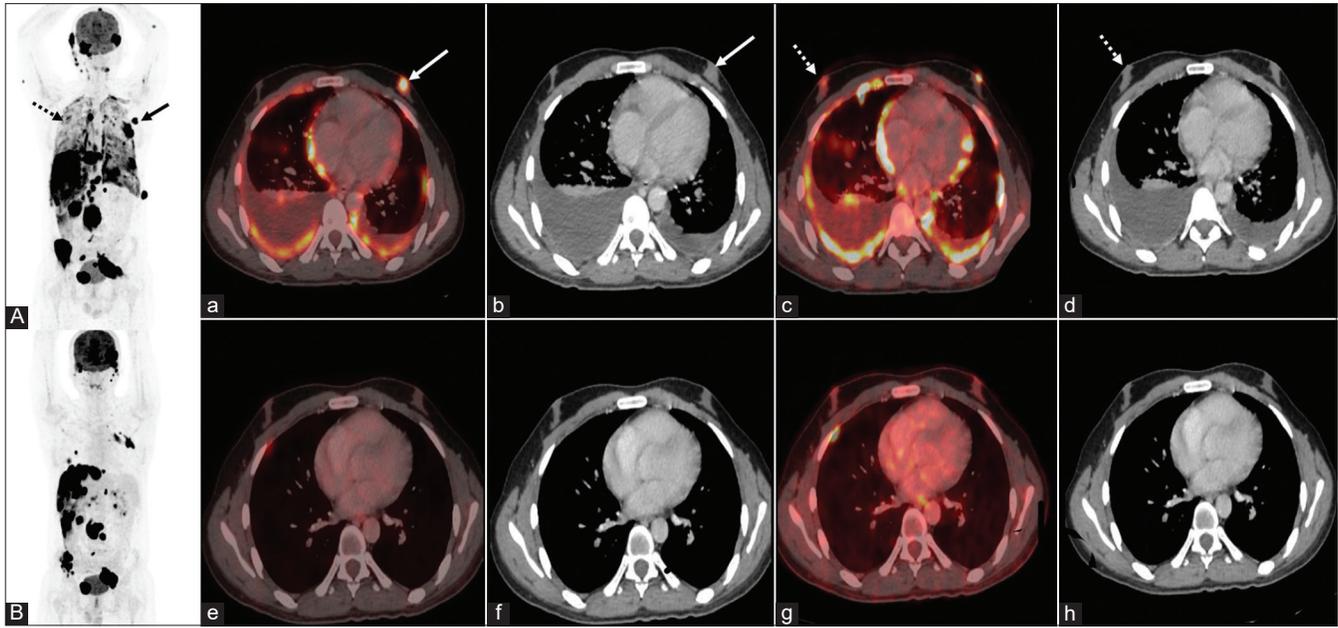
(A) MIP image showing an increased FDG uptake in bilateral breasts (black dashed and solid arrow), (B) MIP image showing resolution of FDG uptake in bilateral breasts. Top row: Axial fused PET/CT images (a and c) and CT images (b and d) show focal increased FDG uptake in the left breast parenchyma (white solid arrow) and right breast parenchyma (white dashed arrow). Bilateral pleural and pericardial deposits are also noted with bilateral pleural effusion. Bottom row: Axial fused PET/CT images (e and g) and CT images (f and h) show complete resolution of FDG uptake in both breast parenchyma. Resolution of the previously seen bilateral pleural and pericardial deposits with bilateral pleural effusion. FDG: Fluorodeoxyglucose, PET/CT: Positron emission tomography/computed tomography, MIP: Maximum intensity projection
